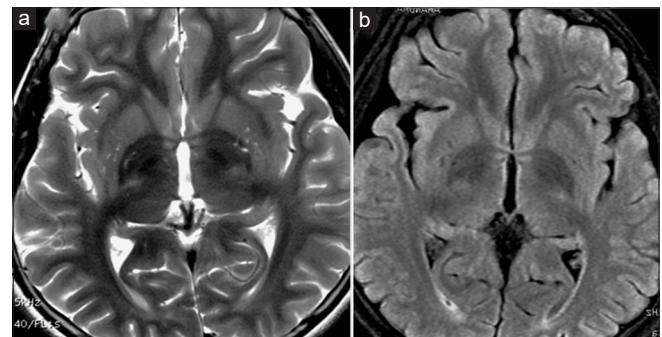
(a and b) Magnetic resonance imaging brain (T2-weighted sequence and FLAIR) shows prominence of Virchow-Robin spaces and T2 hyperintensities in bilateral basal ganglia
